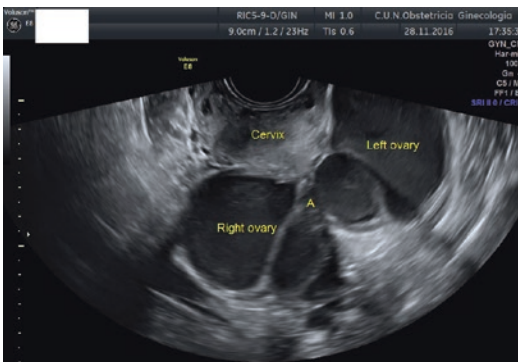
Transvaginal ultrasound showing the two ovaries containing several ovarian endometriomas (E) and adhered one to each other (A), the so-called kissing ovaries
